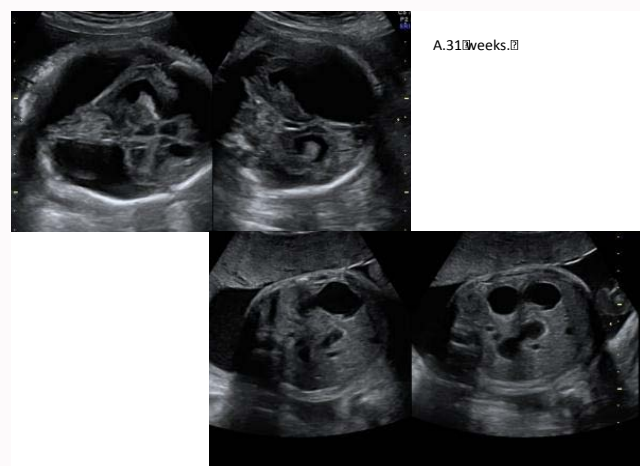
Ultrasound follow-up. The remaining cortex in the frontal lobe and the intestinal dilatations.
